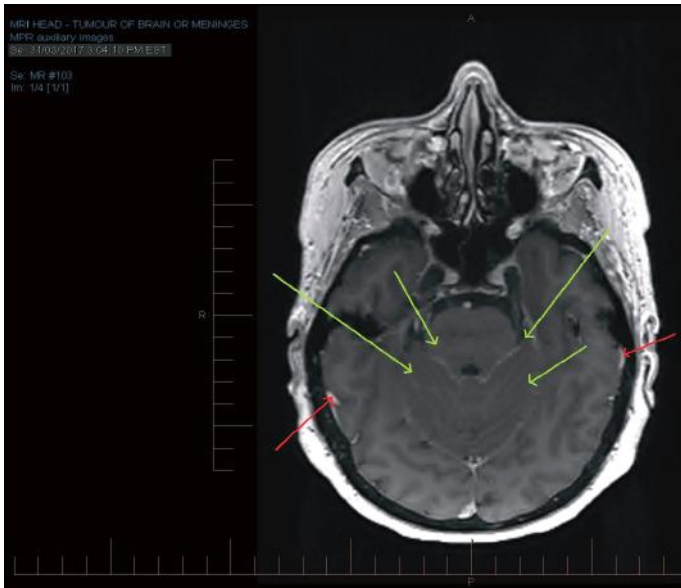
MRI brain (axial view) showing leptomeningeal tumour infiltration in the posterior fossa. Green arrows denote multiple linear hyperintensities representative of enhancing metastatic involvement of the cerebellar folia and brainstem. There is also nodular thickening of the pachymeninges consistent with metastatic infiltration (red arrows).
